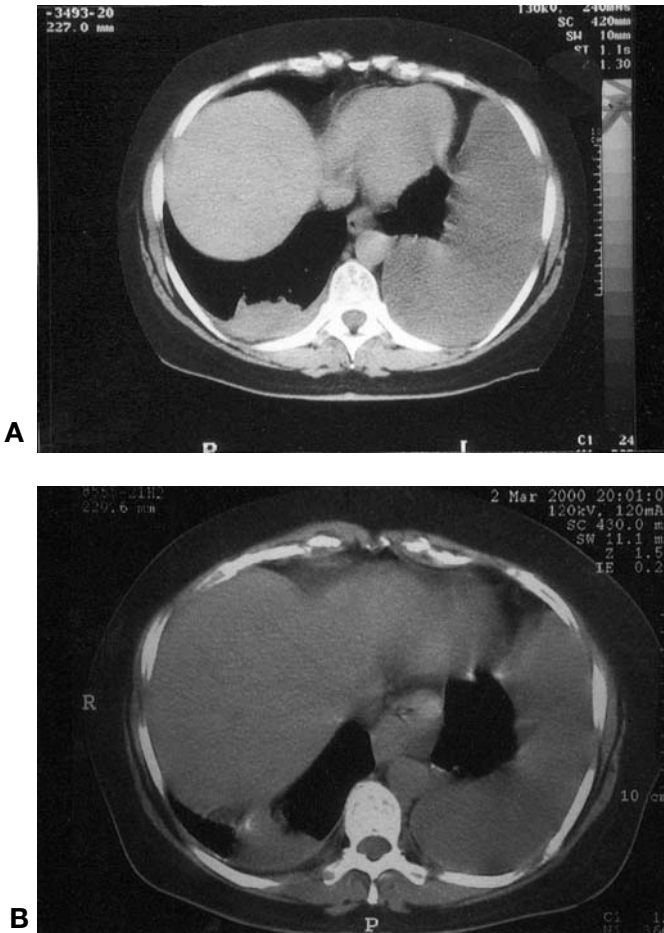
A Chest CT scan, showing a large amount of left-sided pleural effusion and a small amount of loculated, right-sided pleural effusion with parenchymatic changes. B Chest CT, same patient, same level, 3 years later: amount and appearance of the bilateral pleural effusion remain almost unchanged.
